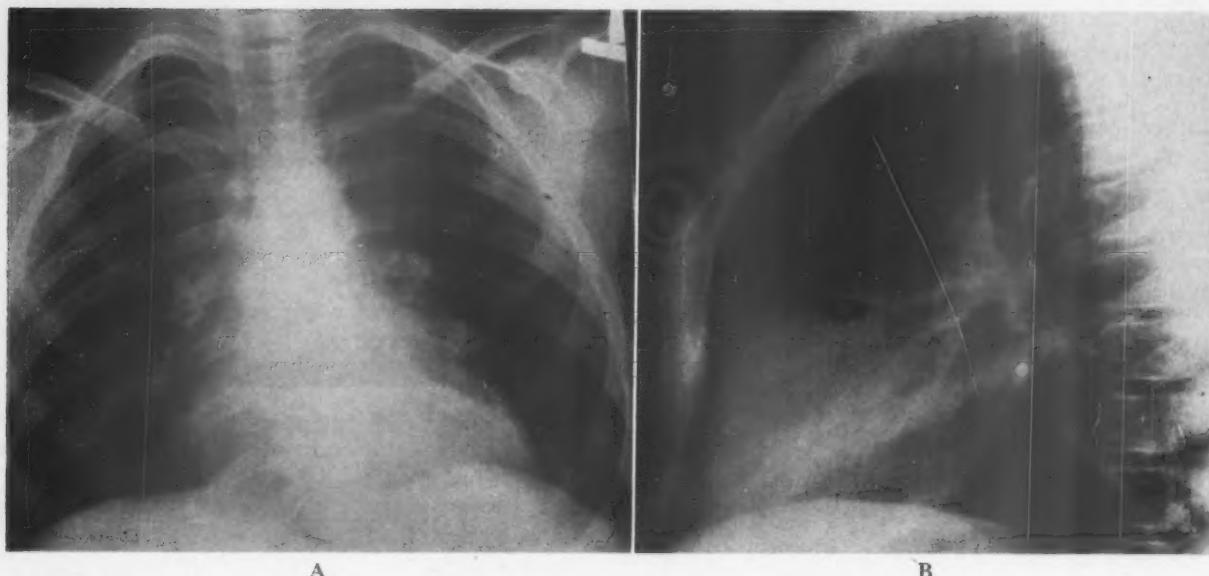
Roentgenograms of the chest* in posteroanterior (A) and left lateral projection (B). Note normal lung vascularity, enlarged right ventricle with increased contiguity of surface to the bulging anterior thoracic wall, and slightly widened aorta.
